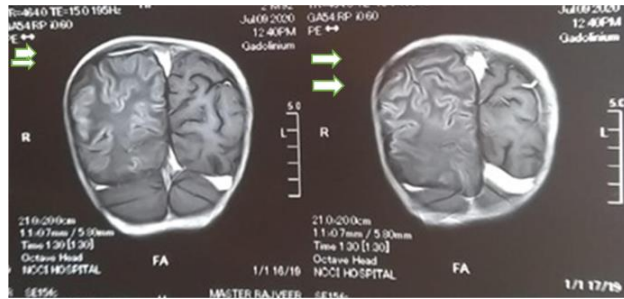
MRI brain coronal images revealed cortical and subcortical large area of abnormal signal intensity seen in fronto-parietal and occipital cortex on the right side along with laminar necrosis
